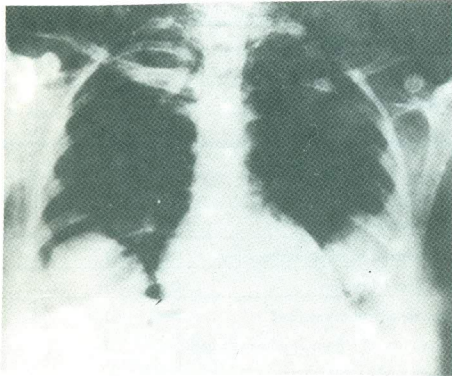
Plain x-ray chest with bilateral basal hydatid cysts.
